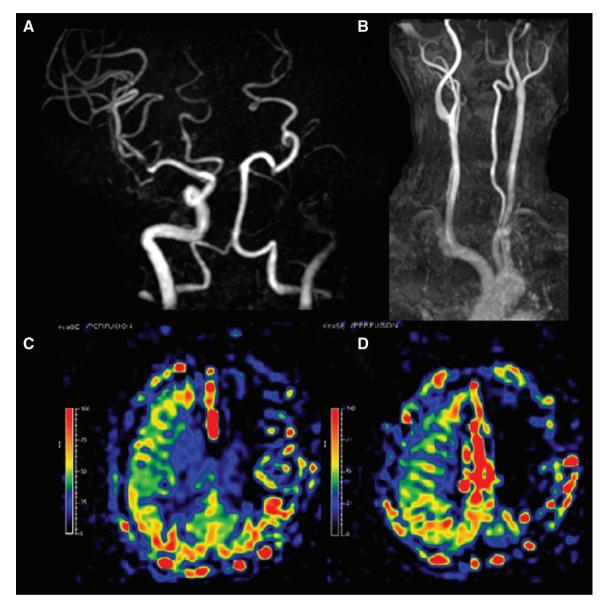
MRA revealed occlusion of the left ICA (A and B). MRI ASL images suggested extensive hypoperfusion of the left cerebral hemisphere (C and D). ASL: arterial spin-labeling; ICA: internal carotid artery; MRA: magnetic resonance angiography; MRI: magnetic resonance imaging
